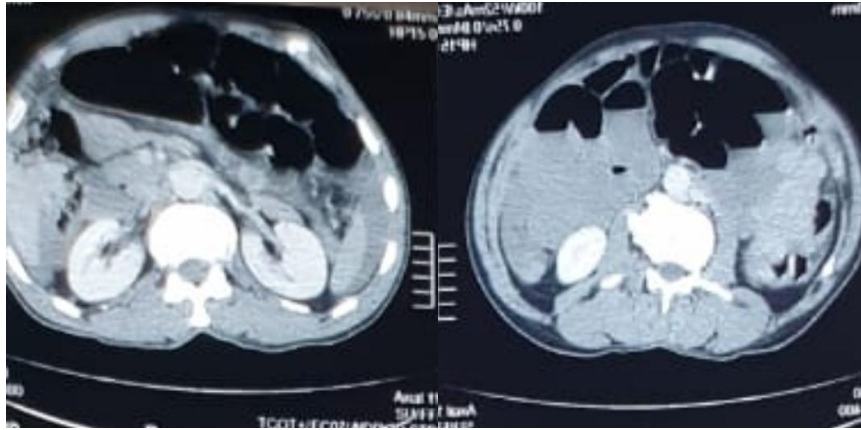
Abdominal CT scan showing central bowel distension with a tight and extensive 33 mm stenosis
